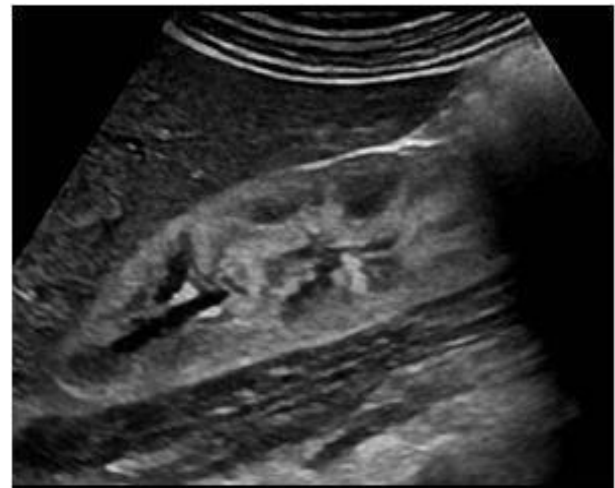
Glomerulonephritis ultrasound
